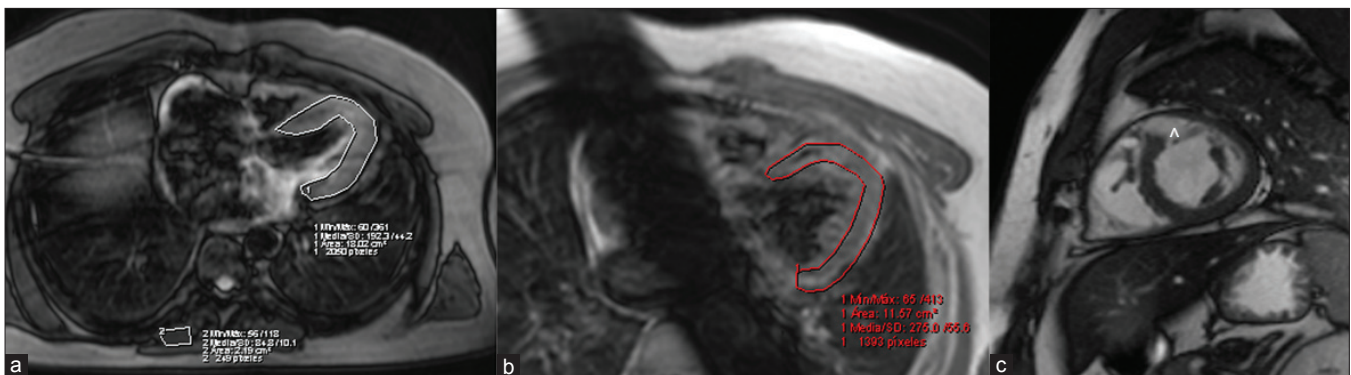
Magnetic resonance imaging examinations to assess myocardial inflammation. (a) Transverse T2-weighted triple-inversion-recovery magnetic resonance image showing a normal edema ratio. (b) Postcontrast transverse T1-weighted fast spin-echo magnetic resonance image showing a normal global relative enhancement. (c) Mid-ventricular short-axis with late gadolinium enhancement showing thinning of the anteroseptal segment of the left ventricle (arrowhead) and normal delayed enhancement in the left ventricular walls. In B an additional saturation section is positioned across the atria to reduce signal from slow-flowing blood. ER and gRE are calculated according to the method of Friedrich *et al.*^[5]
